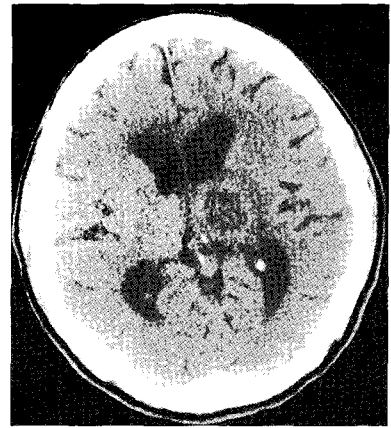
Brain computed tomography shows much resolved intracranial hemorrhage in left thalamus and slightly resolved intraventricular hemorrhage.
